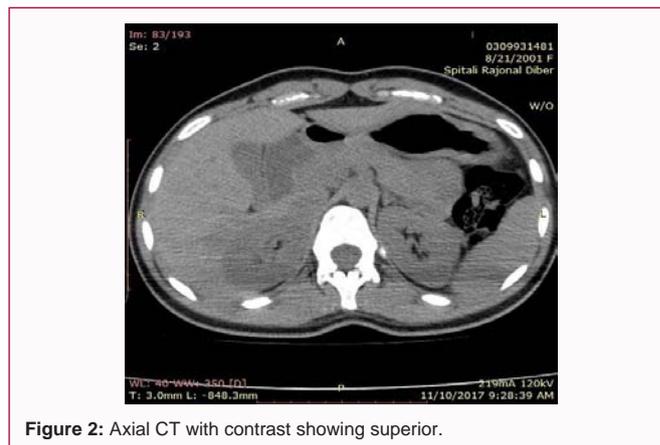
Axial CT with contrast showing superior.
